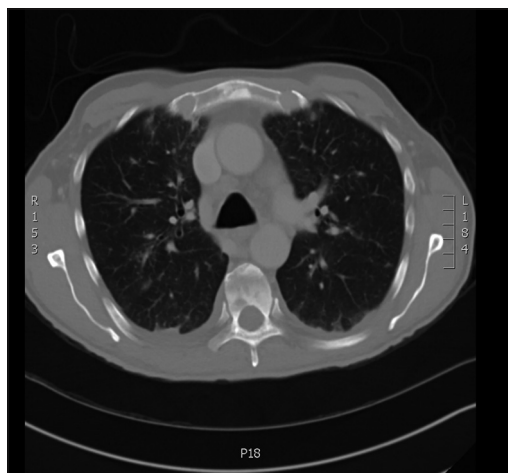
Computed tomography scan of the chest on admission
